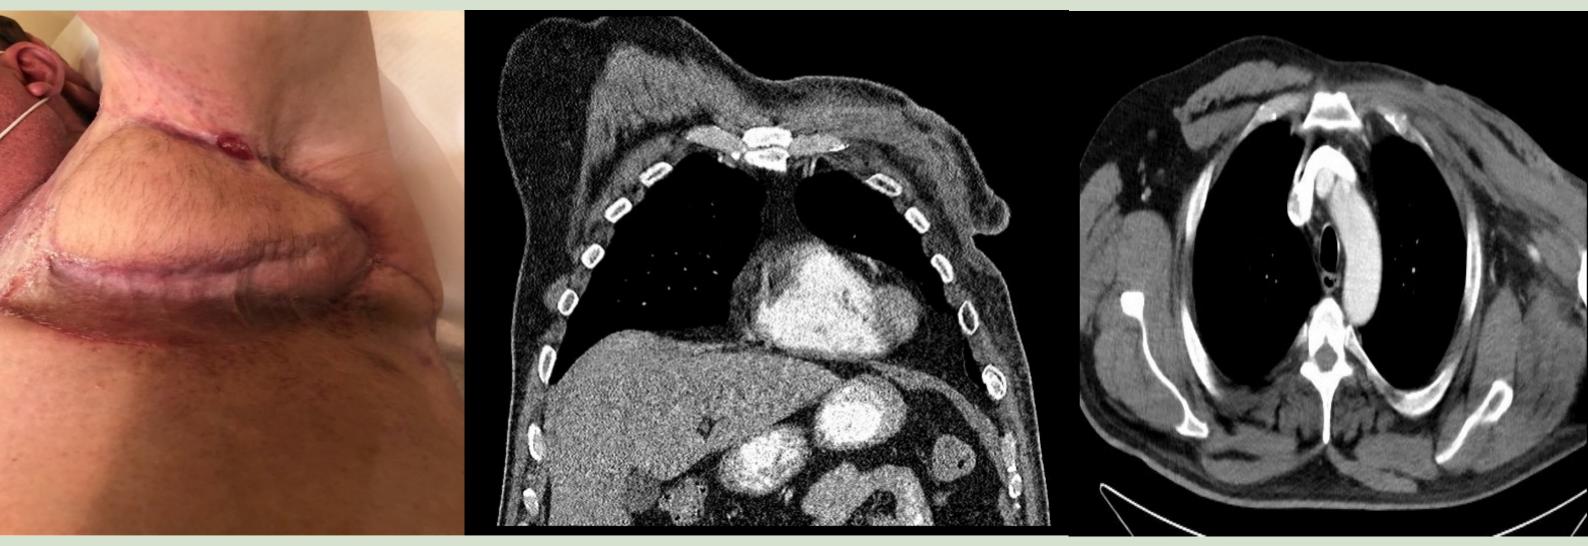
CT- Chest w/ contrast shows no evidence of metastatic disease, local/regional tumor recurrence, or axillary lymphadenopathy.
